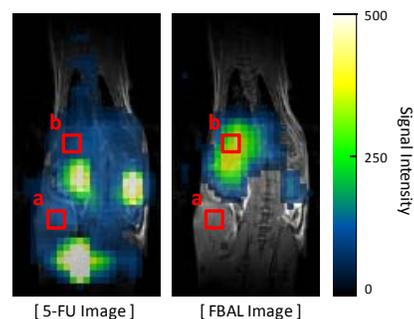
In vivo MRI ( $^{19}\text{F}-^1\text{H}$  image merged) (ROI-a: Tumor, ROI-b: Liver)
